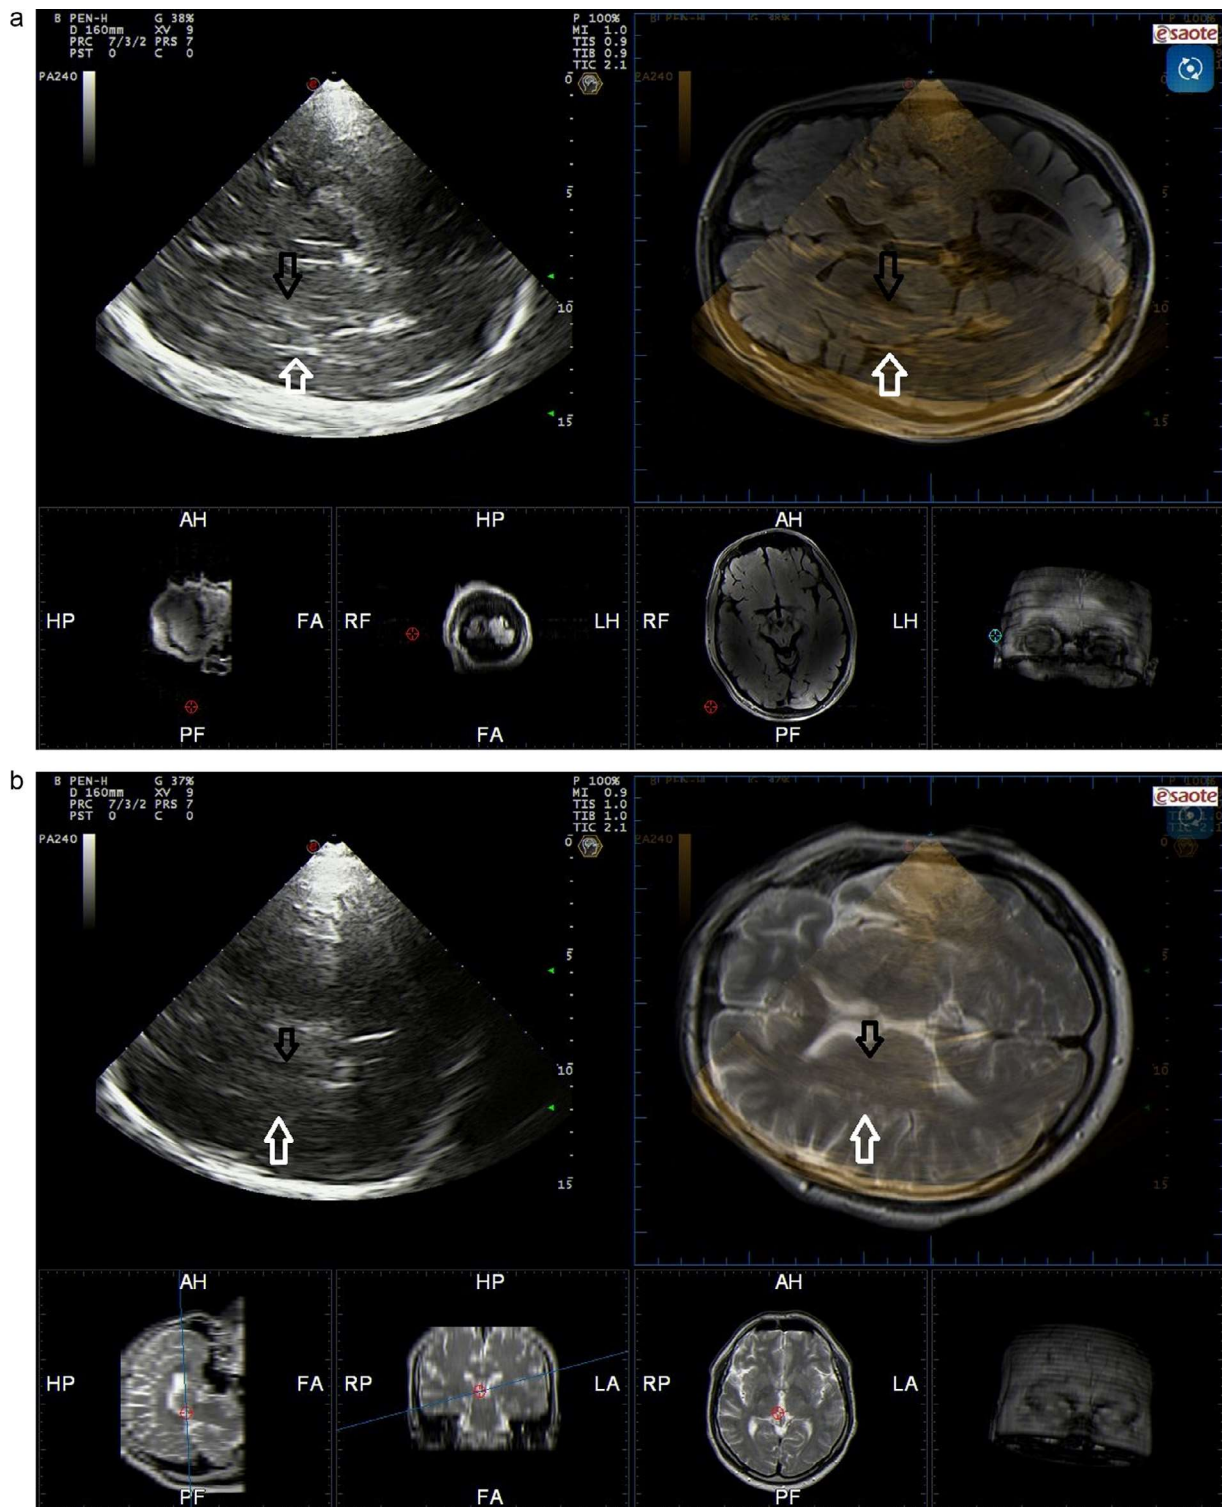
Fusion imaging of transcranial sonography and magnetic resonance in the thalamic plane. (a) Increased echogenicity of lentiform nucleus and insula in patient with Wilson's disease. (b) Normal echogenicity of lentiform nucleus and insula in patient with early onset Parkinson's disease.
